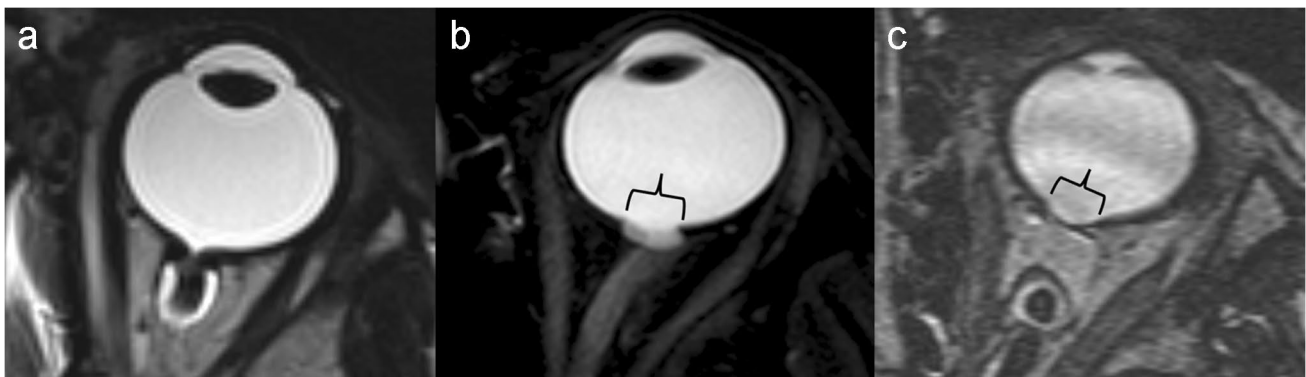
a Note typical MRI findings of MGDA, as described in Fig. 2a above. b Coloboma. Note a defect in the posteroinferior left globe, with a normal left retrobulbar optic nerve. c Staphyloma. Note broad-based thinning of the posterior globe, remote from the optic nerve head insertion
